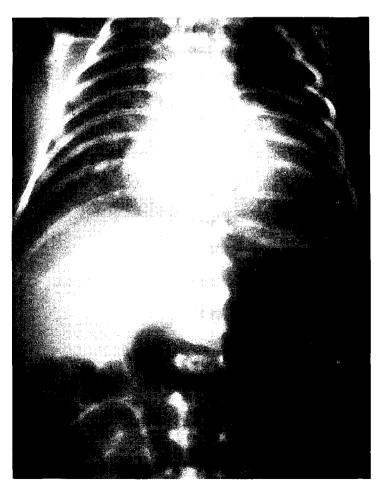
Chest X-ray shows cardiac enlargement.
